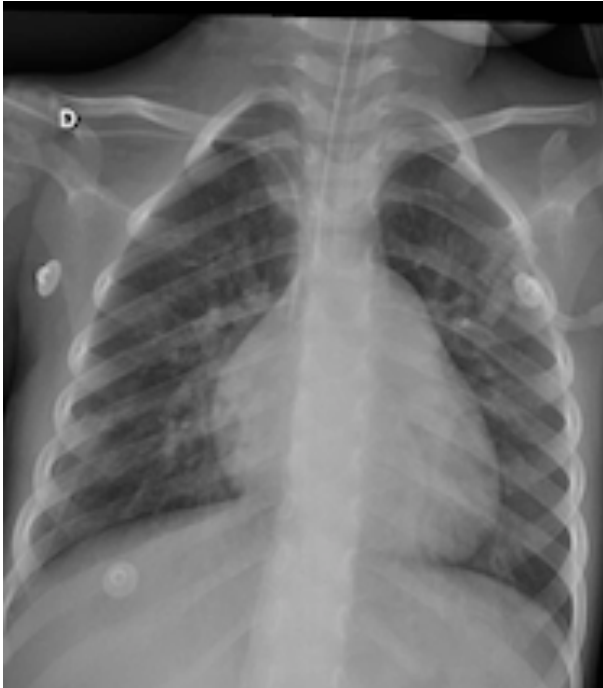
Chest radiograph 48 hours after surgery when the patient had improved
